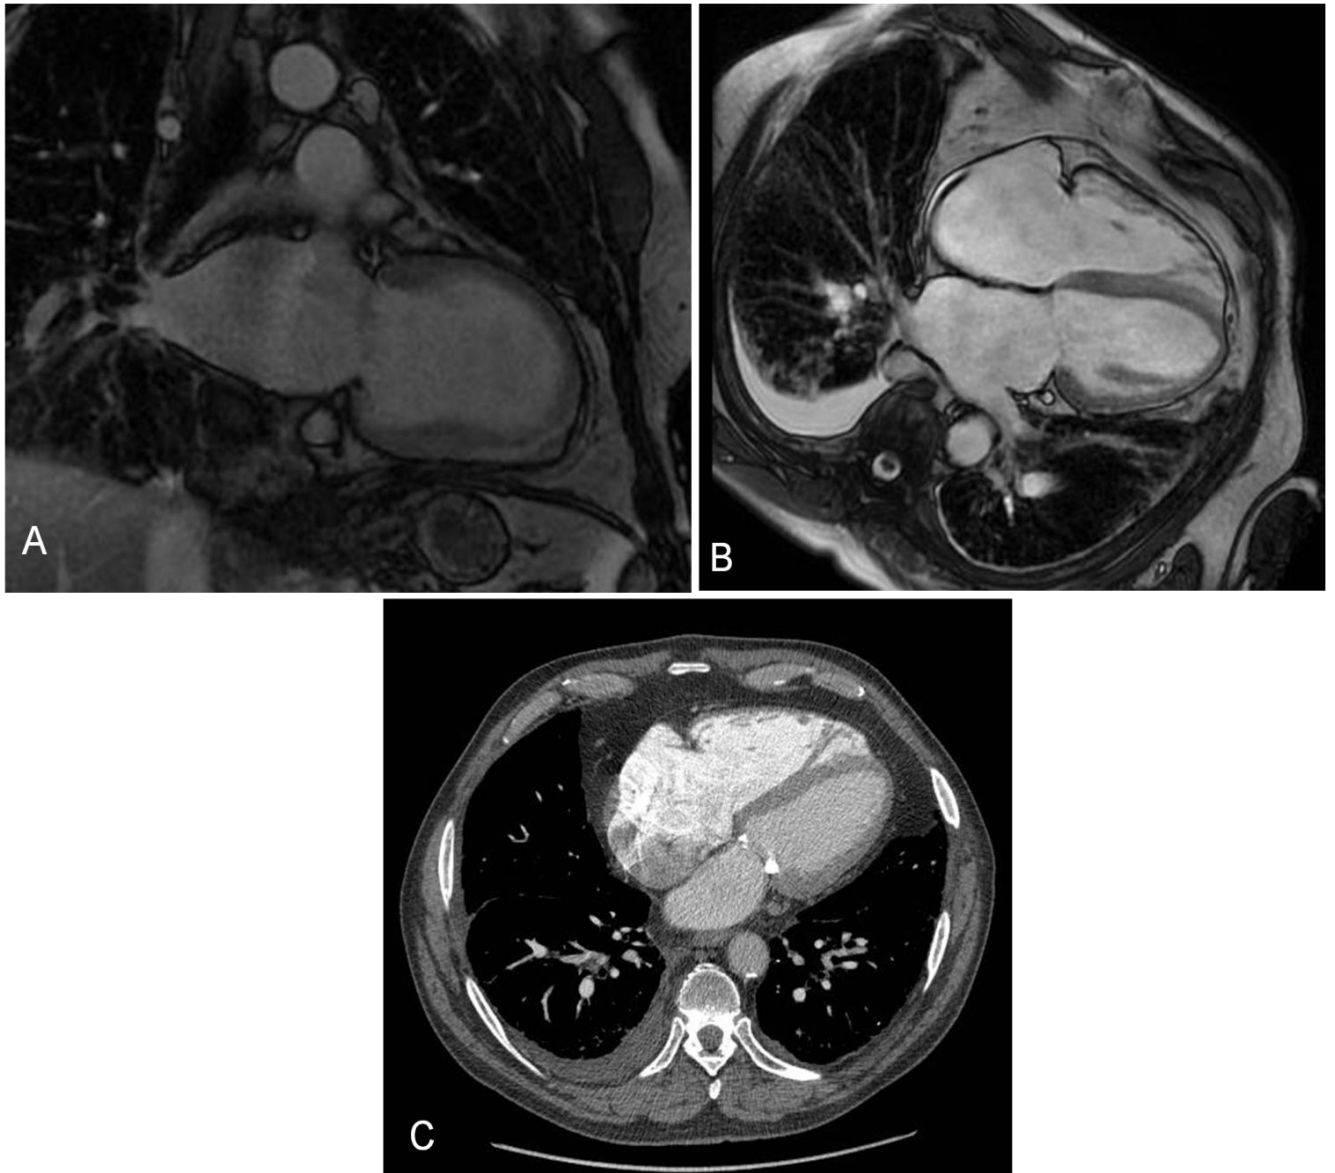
Dilatation of the LV on the LVLA view (A) and 4 chamber view. CT show mitral valve calcification and pleural effusion
